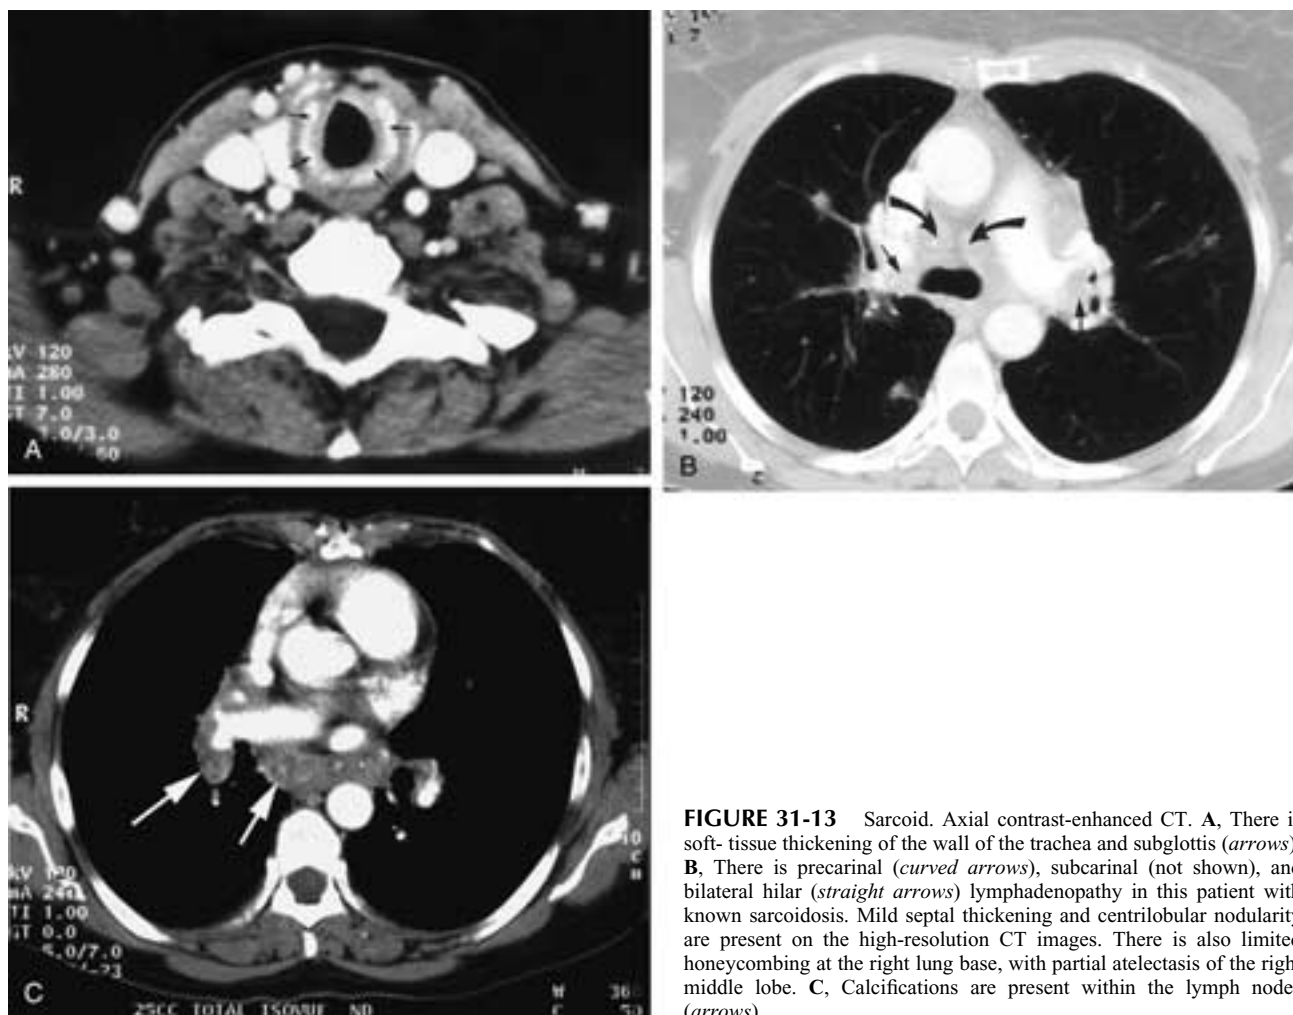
Sarcoid. Axial contrast-enhanced CT. A, There is soft-tissue thickening of the wall of the trachea and subglottis (*arrows*). B, There is precarinal (*curved arrows*), subcarinal (not shown), and bilateral hilar (*straight arrows*) lymphadenopathy in this patient with known sarcoidosis. Mild septal thickening and centrilobular nodularity are present on the high-resolution CT images. There is also limited honeycombing at the right lung base, with partial atelectasis of the right middle lobe. C, Calcifications are present within the lymph nodes (*arrows*).
